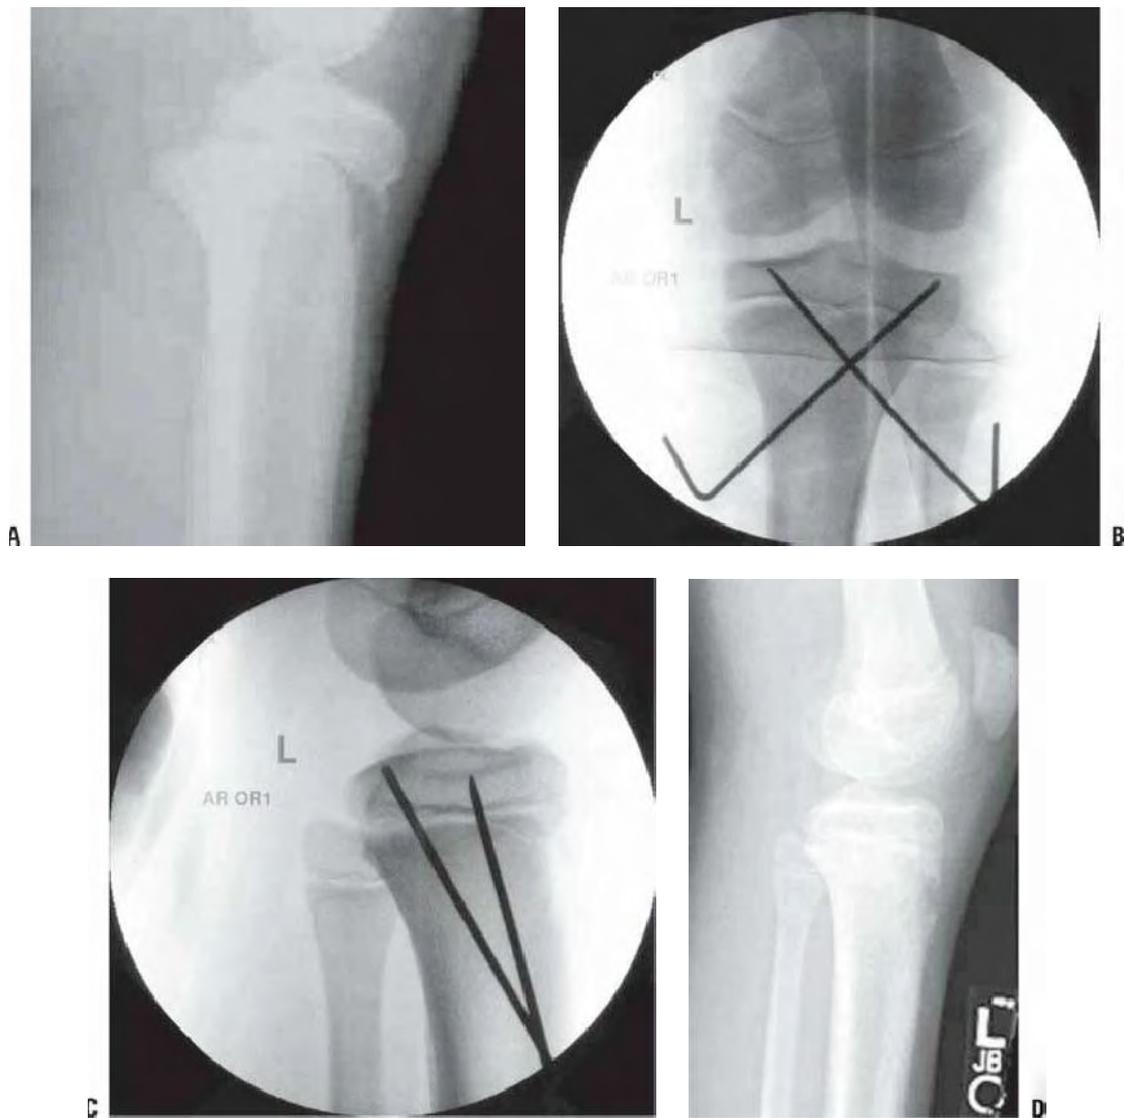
Proximal tibial physeal injury. A: This initial lateral radiograph shows a displaced proximal tibial physeal fracture. B, C: Intraoperative images after closed reduction and internal fixation with two Kirchner wires. D: Lateral radiographs 6 weeks after injury show maintenance of anatomic alignment.
